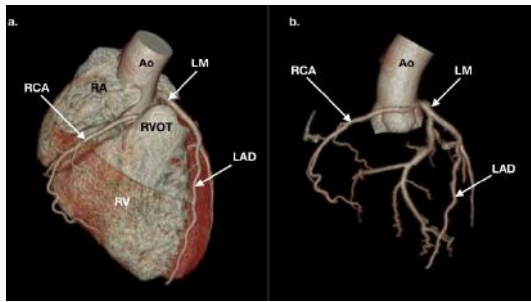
Preoperative CT coronarography: (a) CT coronarography (GE 64 slices dual energy, Volume rendering 3D reconstruction, anterior view and (b) Volume rendering 3D reconstruction without soft tissues, anterior view. RCA: Right Coronary Artery; LM: Left Main; LAD: Left Anterior Descending Artery; RA: Right Atrium; RV: Right Ventricle; RVOT: Right Ventricle Outflow Tract; AA: Ascending Aorta.
